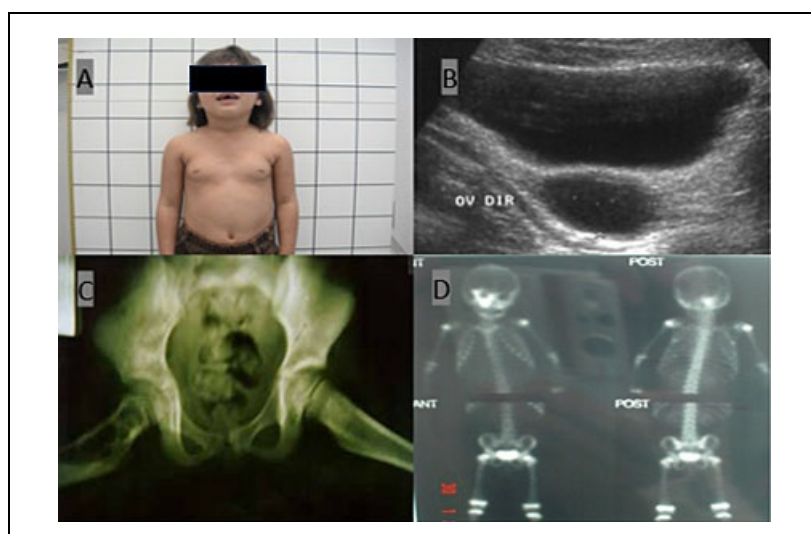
(A) Breast development; (B) simple follicular cyst on pelvic ultrasound; (C) plain radiograph of the pelvis demonstrating an area of bone rarefaction in the right femur; (D) bone scintigraphy
